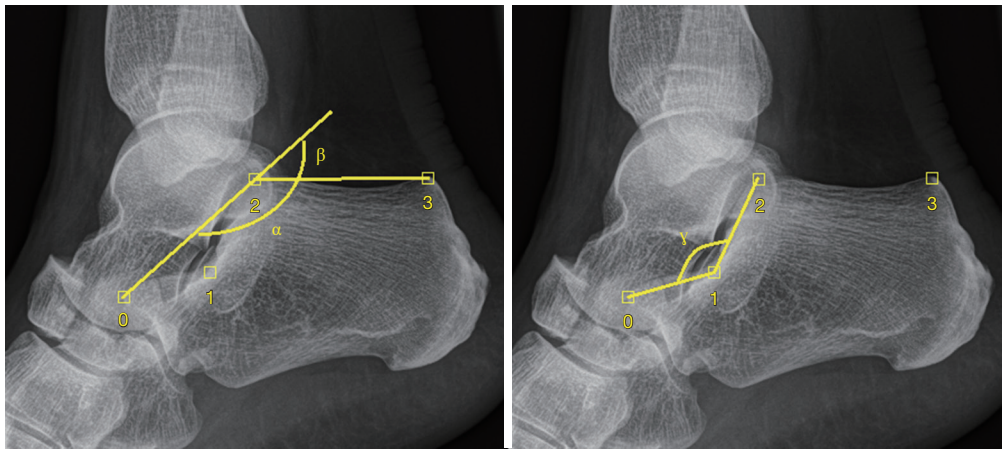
Selected landmarks to calculate Böhler's angle (β , left) and Critical angle of Gissane (γ , right) on conventional lateral radiographs. [0] The most superior point of the anterior process; [1] the most inferior point of the posterior facet; [2] the most superior point of the posterior facet; and [3] the most superior point of the calcaneal tuberosity.
